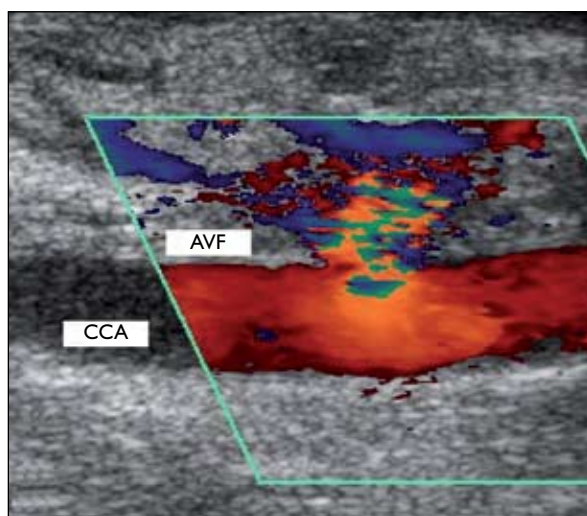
Initial colour Doppler ultrasonogram of the right neck shows an arteriovenous fistula connecting the proximal right common carotid artery to the right internal jugular vein. AVF denotes arteriovenous fistula, and CCA common carotid artery.
